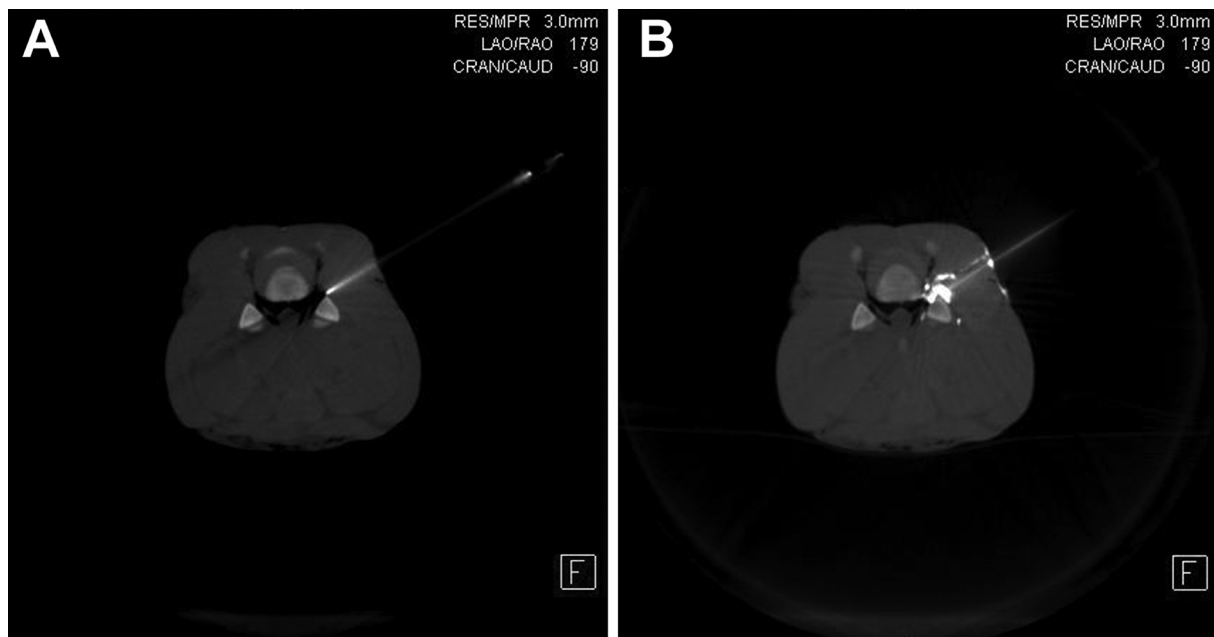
Post-puncture control Dyna-CT images. A) Needle tip position in the axial view of the multiplanar reconstructions. The needle tip is located in the posterior part of the neural foramen. B) Control image of contrast dye distribution. The contrast dye spreads in the ipsilateral nerve root foramen and into the periradicular space.
